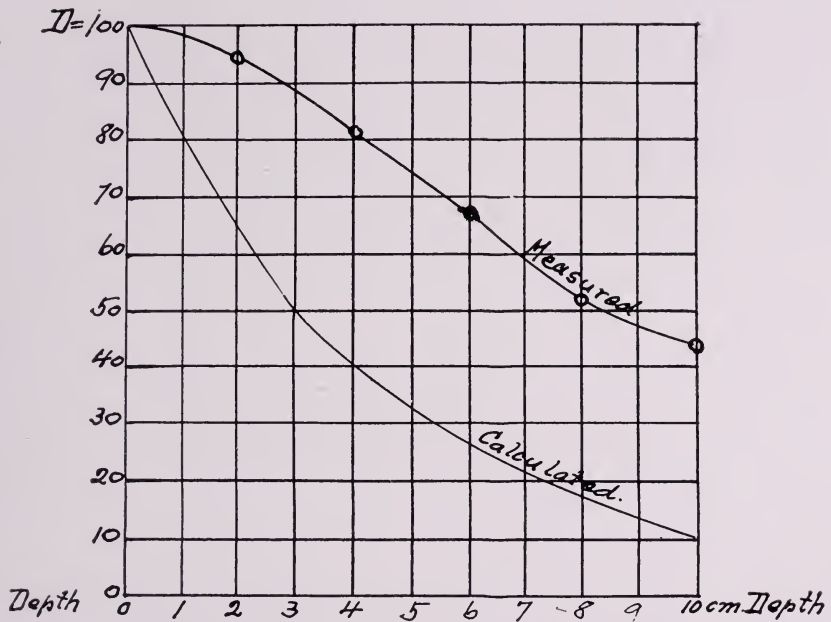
Calculated and Measured Depth Dose of Roentgen Rays filtered with 1mm. Cu. and Size of Field 15 X 15 cm.
